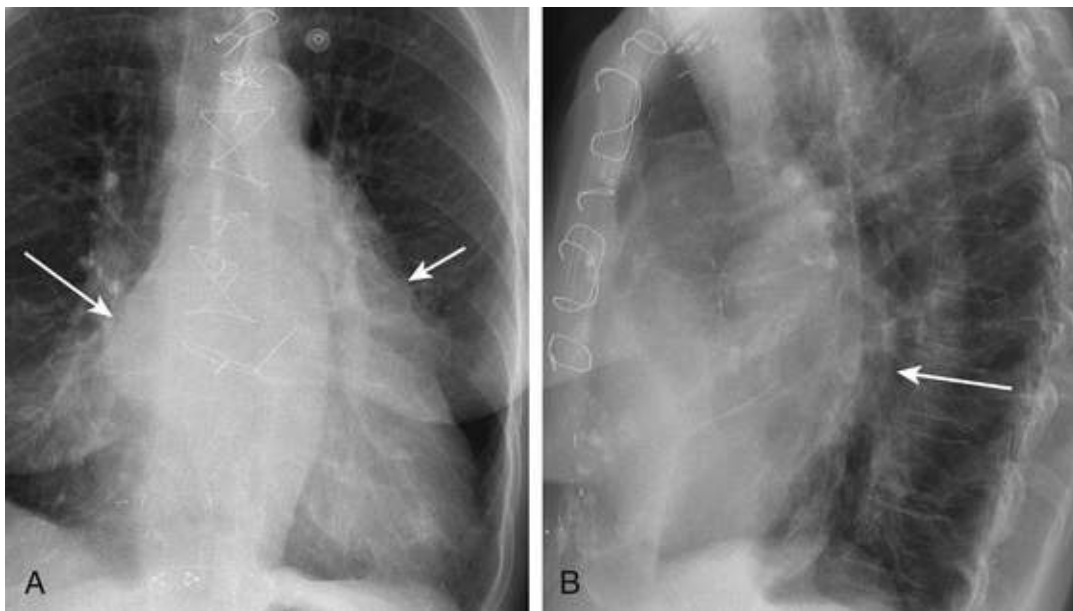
Left atrial enlargement (LAE). Cone-down PA (A) and lateral (B) chest radiographs in patient with mitral stenosis show findings of severe left atrial dilation. A, On the frontal view, a double density sign (*long arrow*) along the right cardiac border and a convexity along the upper left cardiac border (*short arrow*) reveal the LAE. B, Lateral view shows the posterior bulge of the left atrium (*arrow*).
